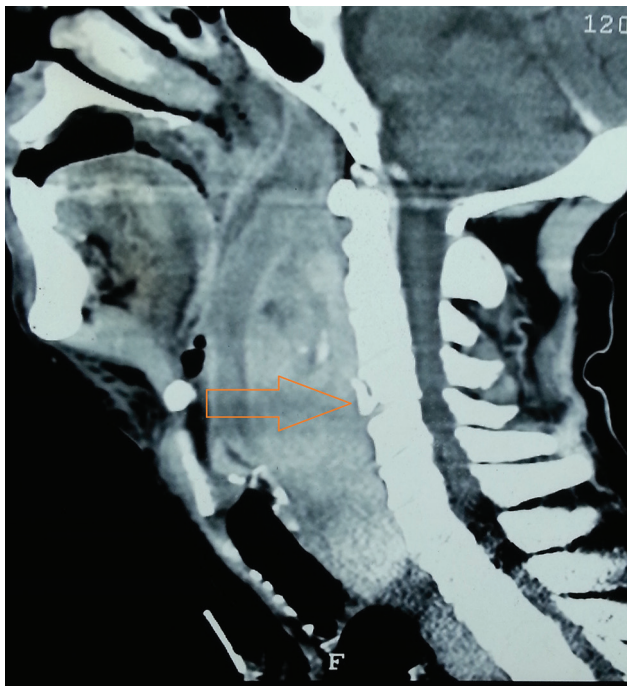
Sagittal view of CECT of neck. Orange arrow shows fracture of C4 vertebral body. CECT, contrast-enhanced computed tomography
